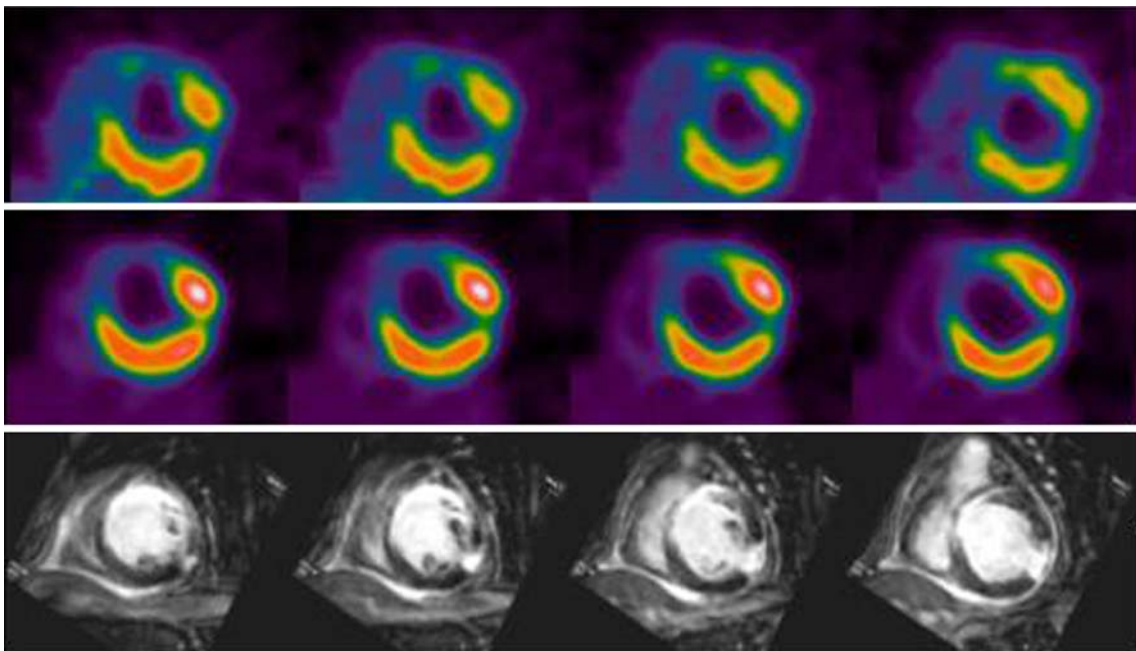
Four short-axis slices of a PET Rb-82 in the *top row*, above, and a PET FDG, in the *second row*. There is a moderate sized, moderately severe defect in the anterior-septal-apical regions on PET Rb-82 that shows the same (MATCHING) severity on FDG and Rb-82 to indicate that the myocardium is no longer viable. In addition, there is a second, small defect in the lateral-inferior region that also shows the same (MATCHING) severity on FDG and Rb-82 to indicate that the myocardium is no longer viable. The *bottom row* shows four short-axis MRI images that show contrast enhancement (*white*) in the same anterior septal and lateral inferior regions that are seen above on PET Rb-82 in the *top row* and PET FDG in the *middle row*. The contrast enhancement extends almost completely from endocardium to epicardium on the MRI, demonstrating a nearly transmural extent of scar tissue, consistent with Figure 1B. Thus, both PET and MRI identified the same two myocardial infarction regions as non-viable.
